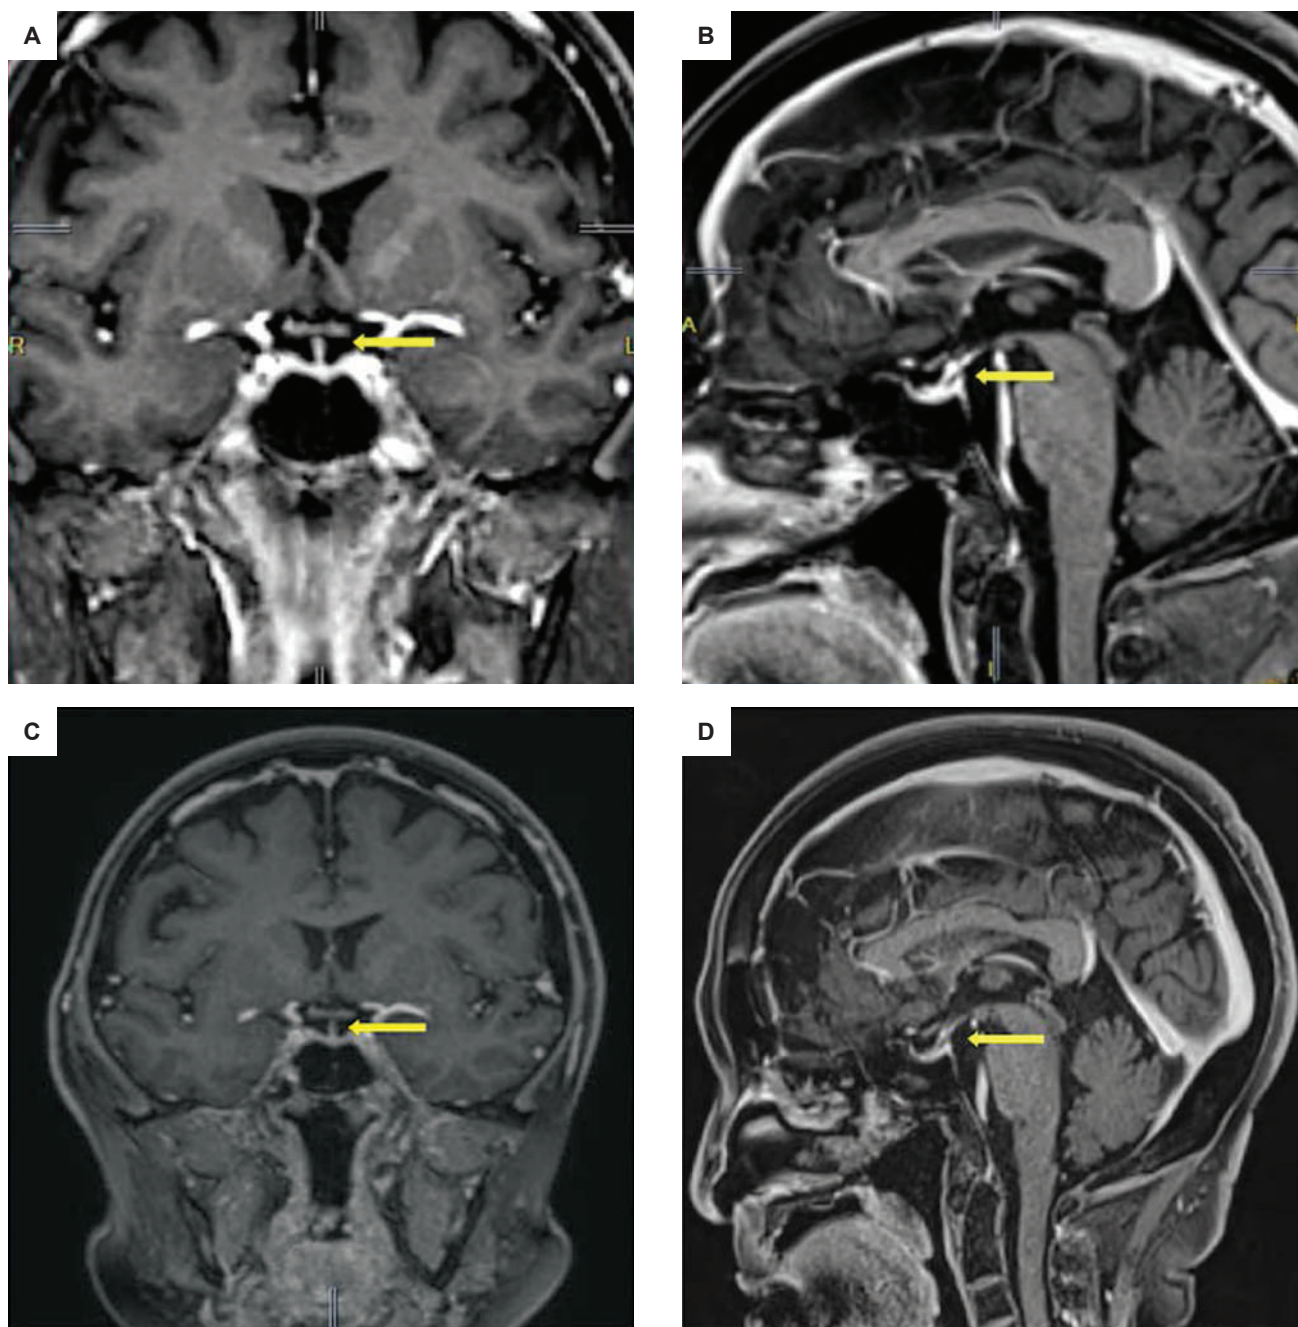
Cranial MRI in (A) coronal and (B) sagittal views after 3 months of steroid therapy showing complete resolution of the sellar nodule. A normal-sized pituitary gland, midline infundibulum and normal optic chiasm on both views (C and D) were seen approximately 6 months after treatment.
